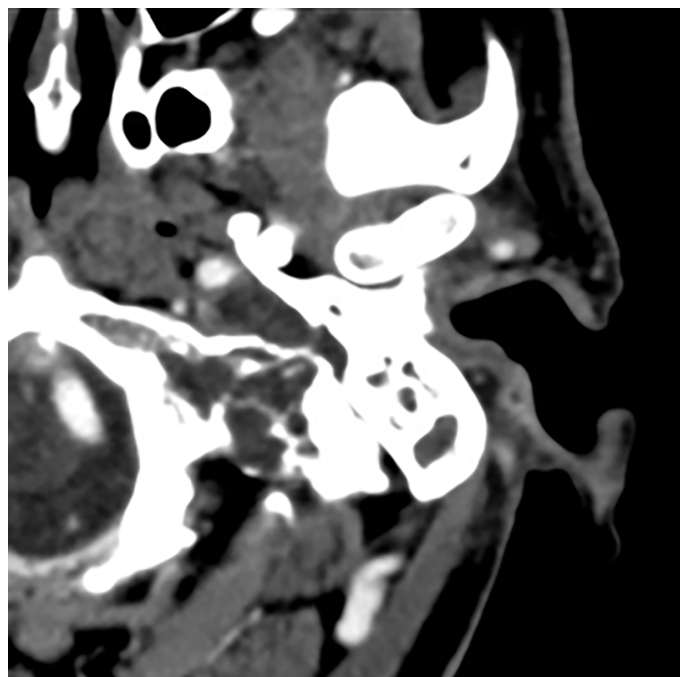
Axial contrast-enhanced CT image demonstrates a low-density soft tissue mass in the left mastoid, the middle ear, and jugular fossa with irregular margins and extensive bone destruction. Tumor localization in the left carotid retropharyngeal space with invasion of the jugular vein.
